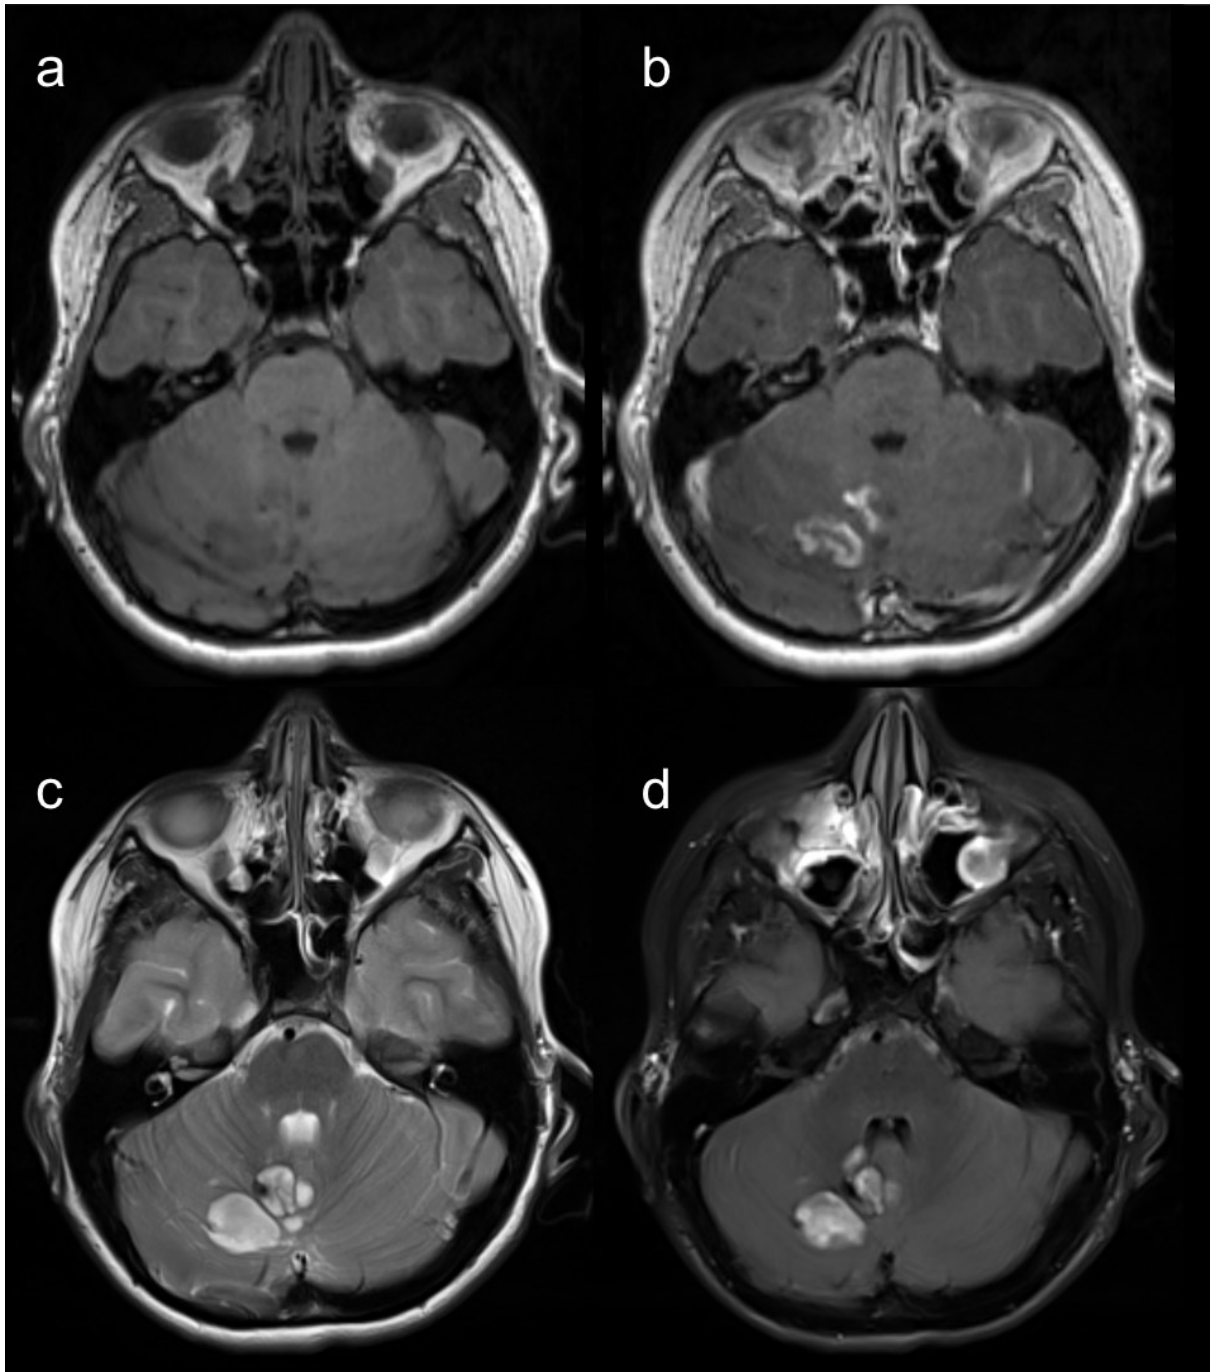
Pre- and post-contrast T1-weighted (a, b), T2-weighted (c), and T2-FLAIR (d) MRI scans of a 12-year-old patient with rosette-forming glioneuronal tumor in the cerebellum. The images demonstrate cystic components and heterogenous contrast enhancement. Data acquired at University Hospital Motol.
